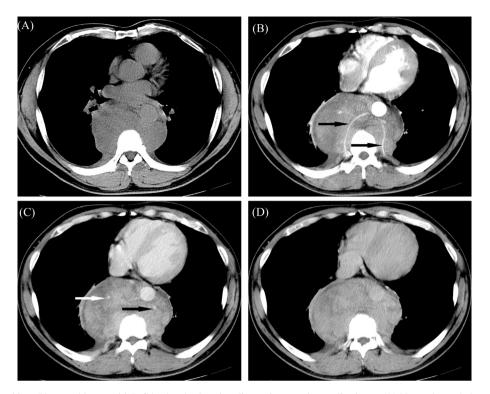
CT images acquired in a 54-year-old man with IgG4-related sclerosing disease in posterior mediastinum. (A) Non-enhanced chest CT image demonstrates an irregular mass in posterior mediastinum, with inhomogeneous attenuation and well-defined margin. Slight bilateral pleural effusion is visible. (B) Contrastenhanced CT in the arterial phase shows the mass locates posterior and lateral to the thoracic aorta. The thoracic aorta, intercostals artery (black arrows), azygos vein and hemiazygos vein are encased and squeezed shift by the mass. (C, D) Contrast-enhanced CT in the venous phase shows the azygos vein (black arrow) and hemiazygos vein (white arrow) with narrowing. The mass presents a gradually heterogeneous enhancement.
